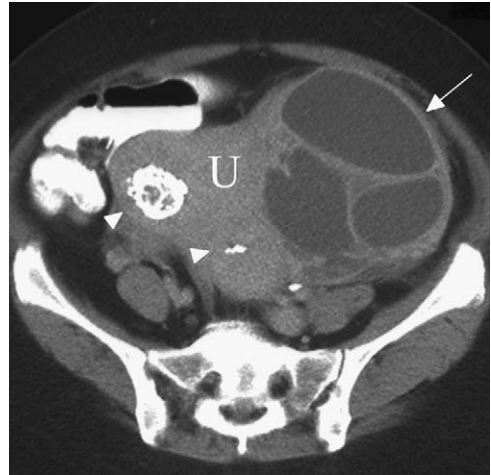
Fibroids, computed tomography (CT). Axial unenhanced CT shows the lobular contour of a myomatous uterus (U), which contains 2 calcified fibroids (arrowheads) and a large, degenerating, cystic-appearing fibroid (arrow).
